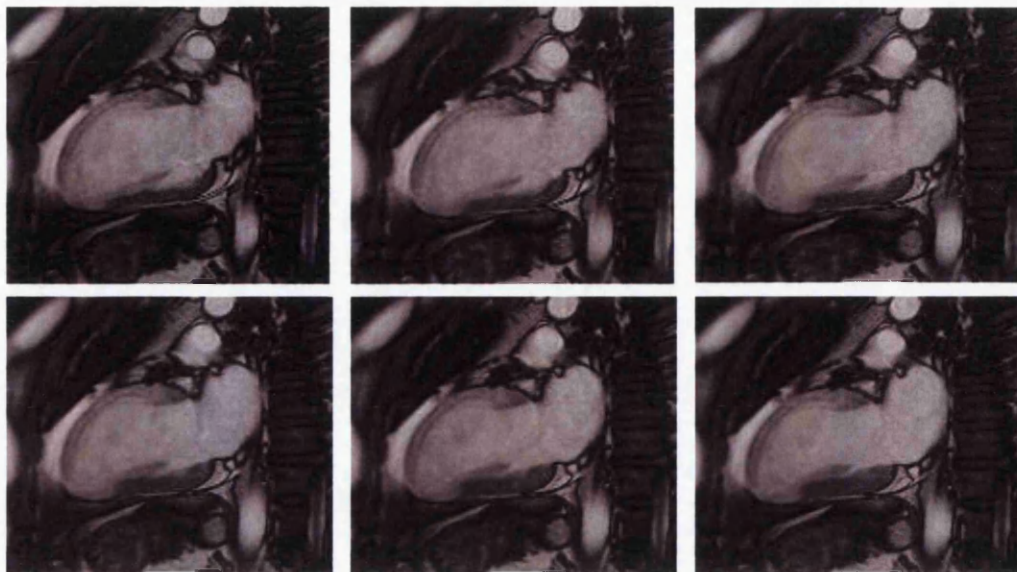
A sequence of post Gd-DTPA MR images from the long axis view.
